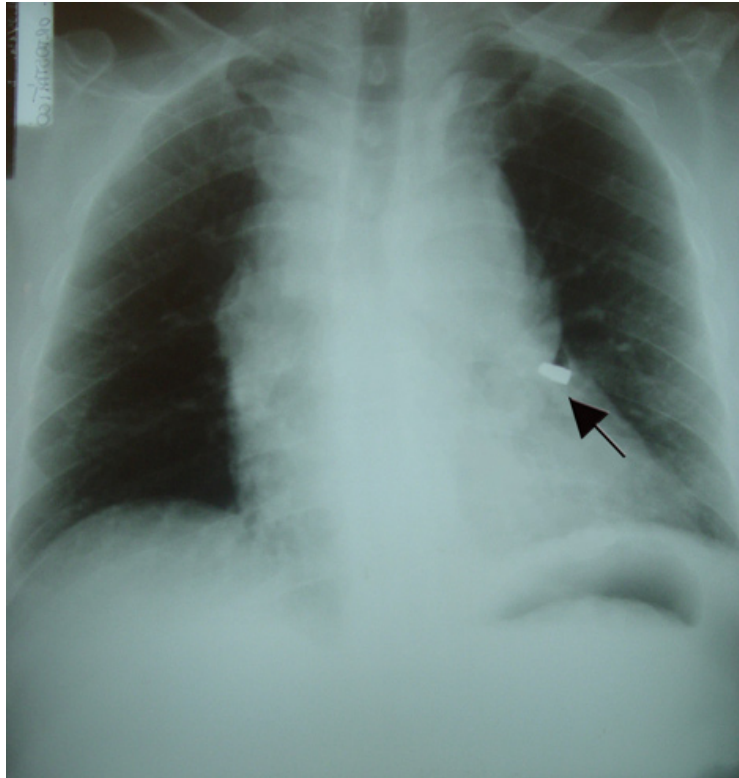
Chest X-ray showing mediastinal widening and a bullet in the left hemithorax (arrow).
